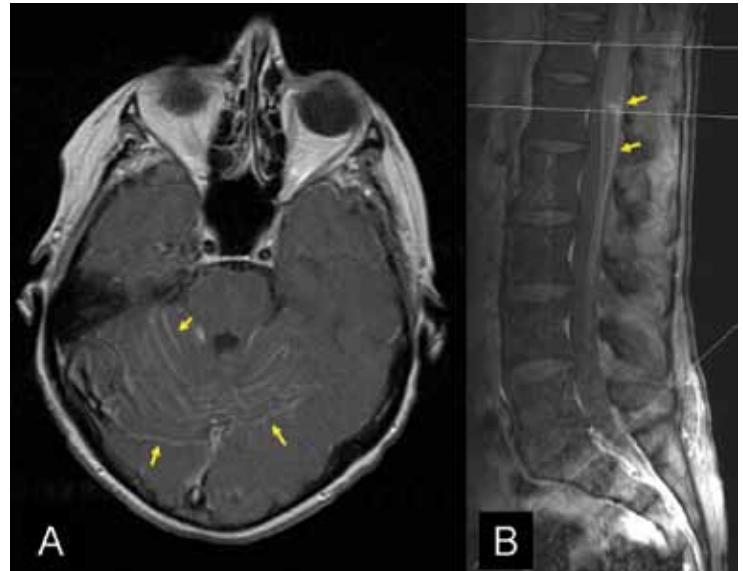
(A) Sulcal enhancement of the cerebellum (arrows) on brain magnetic resonance imaging (MRI), consistent with leptomeningeal metastasis. (B) Leptomeningeal metastasis on lumbar spine MRI with enhancement near the conus medullaris (arrows).
